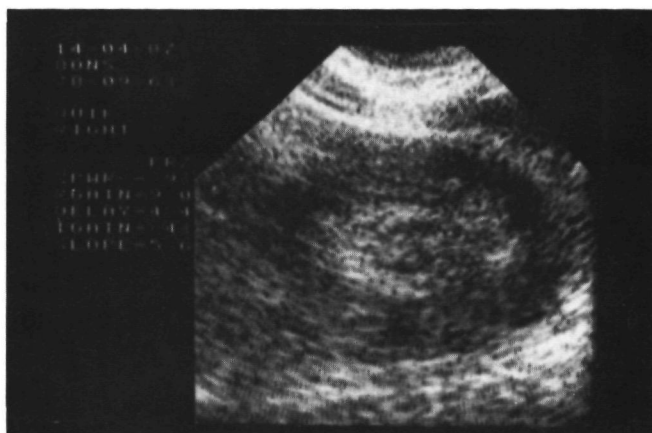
Sonogram of the same patient as in Figure 1 showing a typical multiple concentric ring sign.
